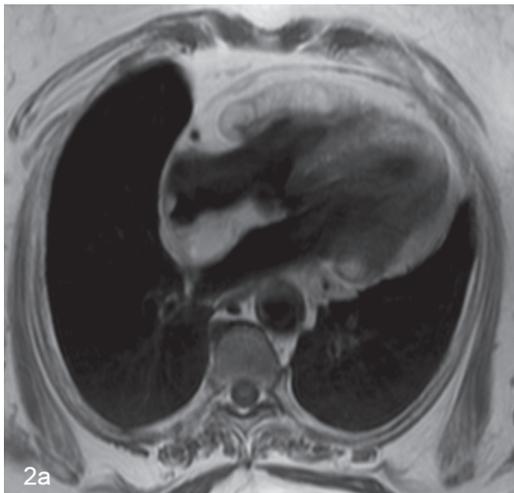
Four chambers view MRI a.T1W
